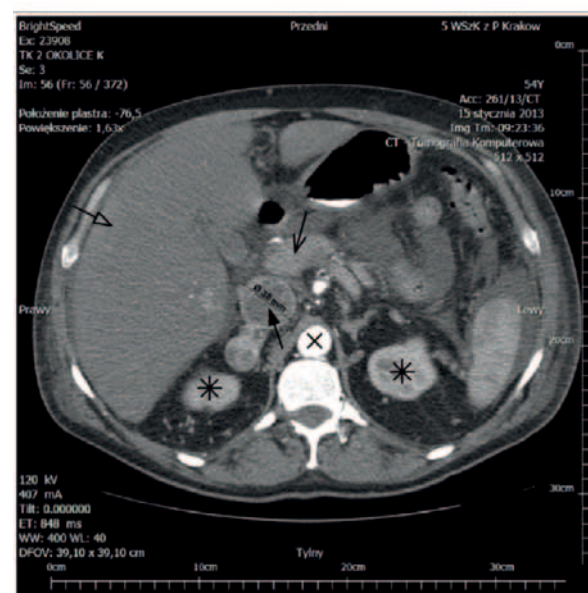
CT scan of abdomen done during first hospitalization. It shows widened (diameter 38 mm), partially occluded inferior vena cava with masses that suggested thrombosis (marked by $\blacktriangleright$). Surrounding organs are marked as followed: liver $\blacktriangleright$, pancreas $\blacktriangleright$, kidneys $*$, aorta $\times$.
